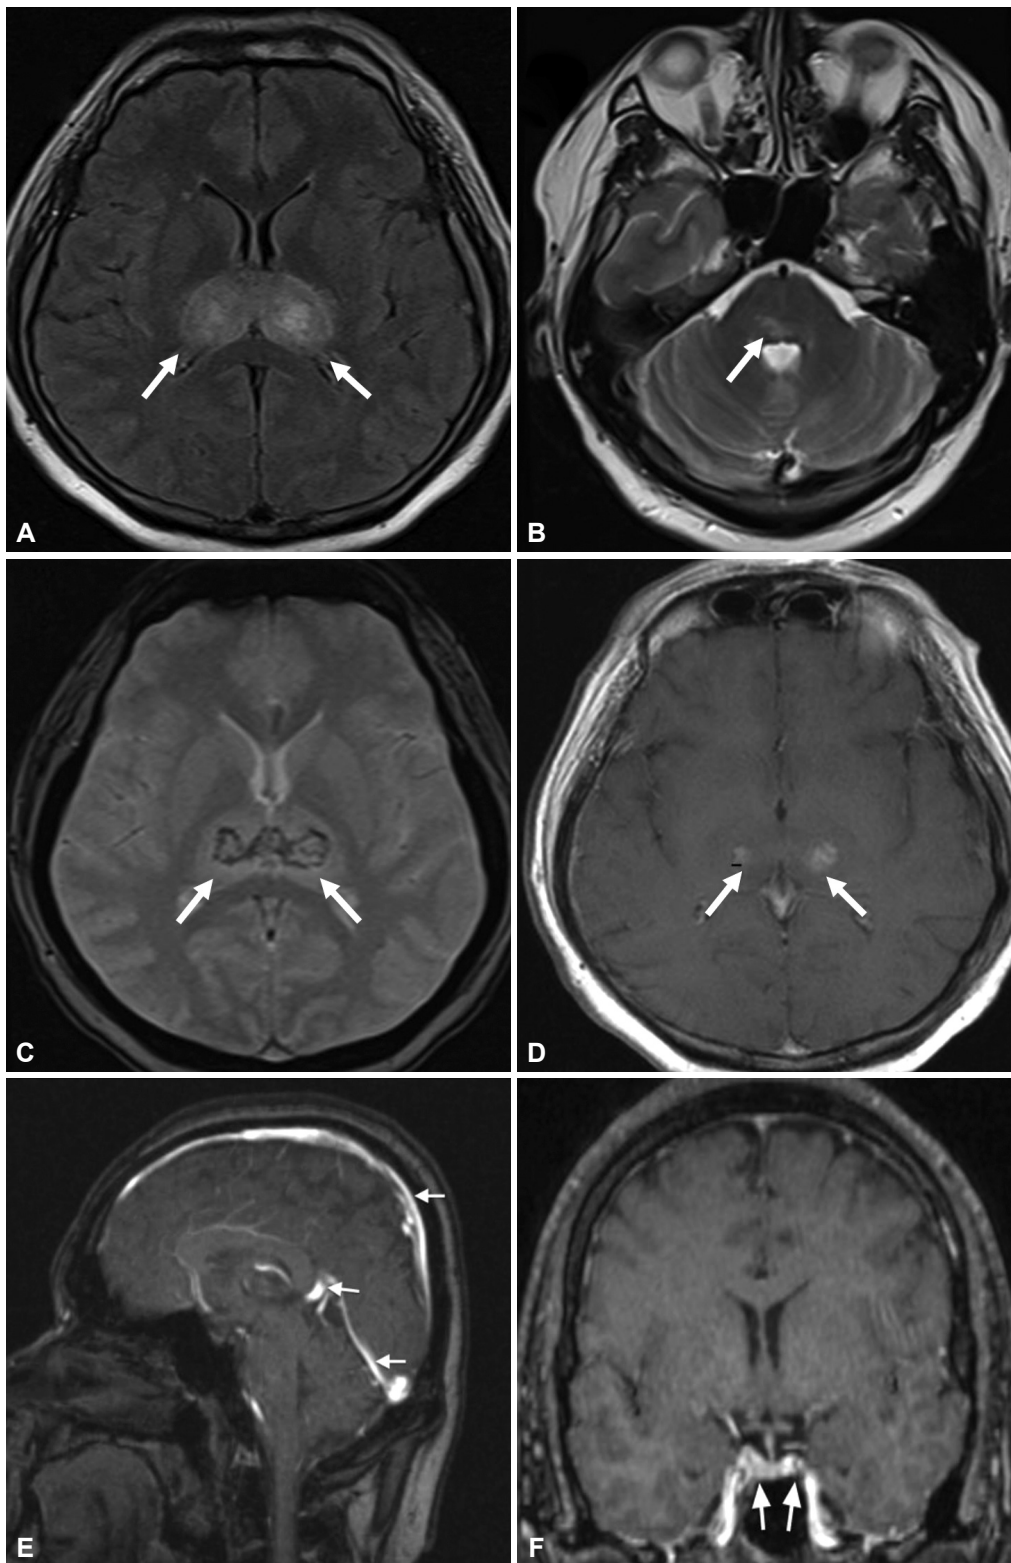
Cranial magnetic resonance imaging of the patient obtained on day 17 of illness. A and B: Axial FLAIR and T2W MRI images demonstrate diffuse hyperintense lesions bilaterally symmetrical within the deep gray matter of the bilateral thalami and right posterior pons (arrows). C: Axial T2W GRE revealed susceptible artifacts within thalamic lesions with hemosiderin deposits (arrows). D: The thalamic lesions showed subtle enhancement on T1W postcontrast (arrows). E: Sagittal venogram TOF showed no filling defect within the superior sagittal sinus, great cerebral vein or straight sinus (arrows). F: Coronal venogram at the level of the cavernous sinuses showed no filling defect within the cavernous sinuses (arrows). FLAIR, fluid attenuated inversion recovery; GRE, gradient echo; TOF, time of flight.
